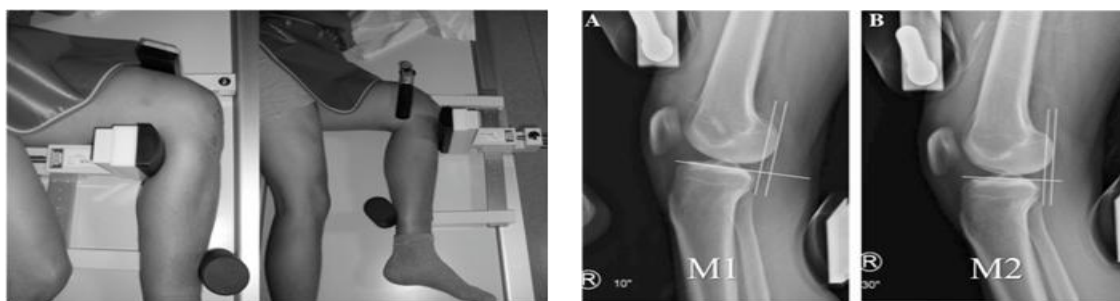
The anterior stress radiography of the knee using a mechanical stress device. The knee is positioned in slight flexion while anterior force is applied to the proximal tibia. Radiographs (A) at 10° and (B) at 30° flexion show increasing anterior tibial translation relative to the femur, enabling objective assessment of anterior cruciate ligament (ACL) instability.
